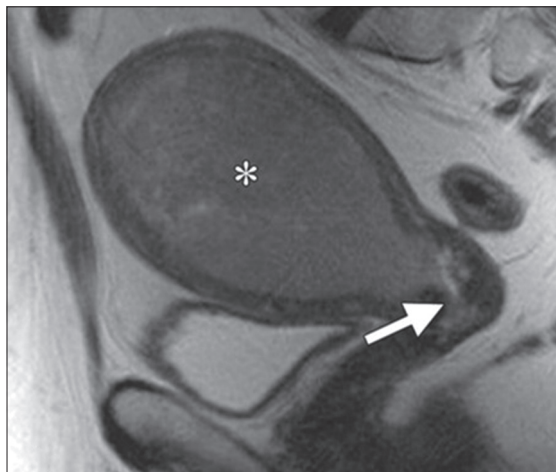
Stage II endometrial cancer in a 64-year-old female. (a) Sagittal T2-weighted magnetic resonance image shows the distention of the endometrial cavity by a tumor (*) that extends into the cervix (arrow). Signal intensity of the tumor is intermediate on T2-weighted with restricted diffusion showing apparent diffusion coefficient values of 0.8–0.9 (images not included here)
